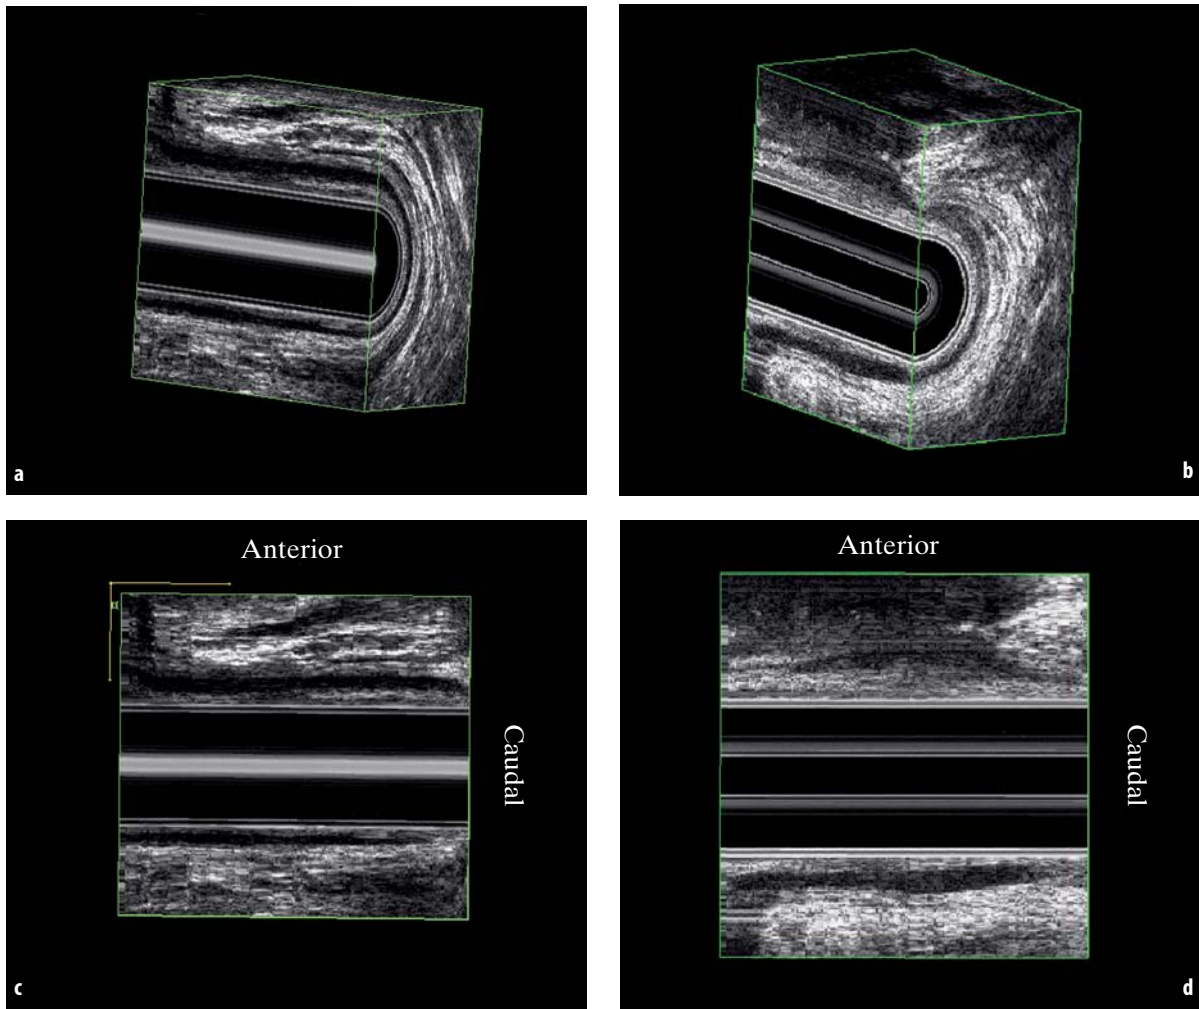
Three-dimensional endosonographic reconstruction demonstrating that the anterior anal sphincter is shorter in the female: male (a), female (b). Sagittal images: male (c), female (d)
